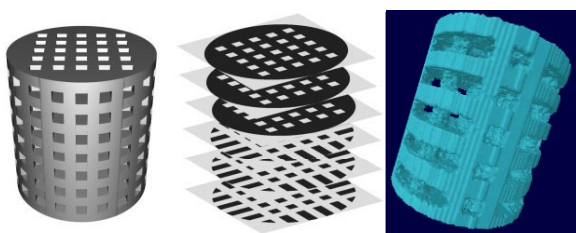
a) CAD model and b) Three-dimensional reconstruction of the 3D printed scaffold as measured with μ CT.
